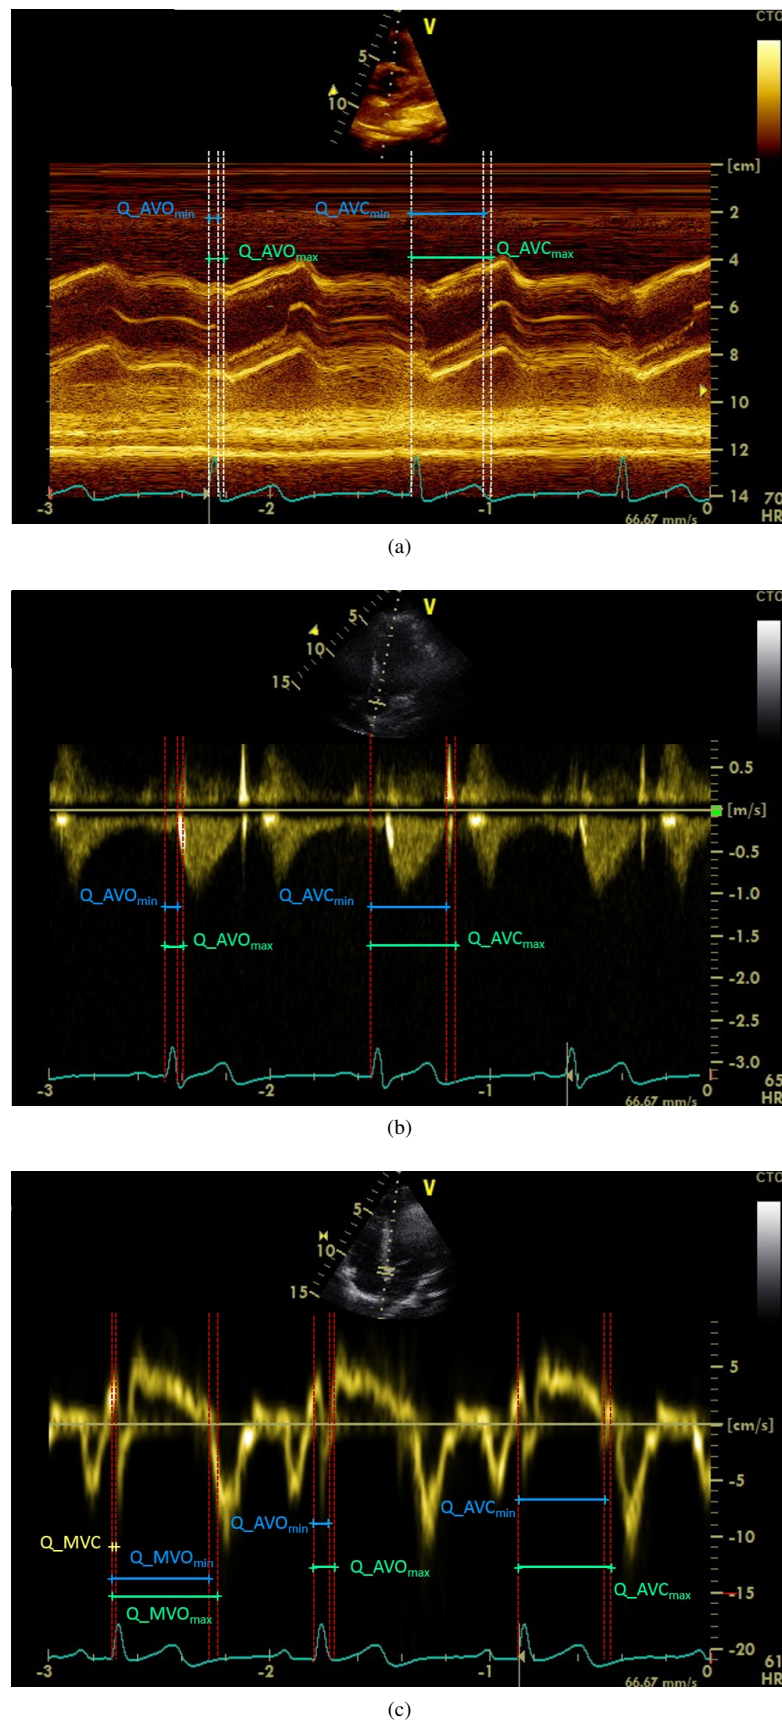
Echocardiogram images captured using (a) M-mode, (b) Doppler flow and (c) TDI modalities. AVO and AVC stand for aortic valve opening and closure. MVO and MVC stand for mitral valve opening and closure. Max and min subscripts represent the start and the end of the echocardiographic intervals.
